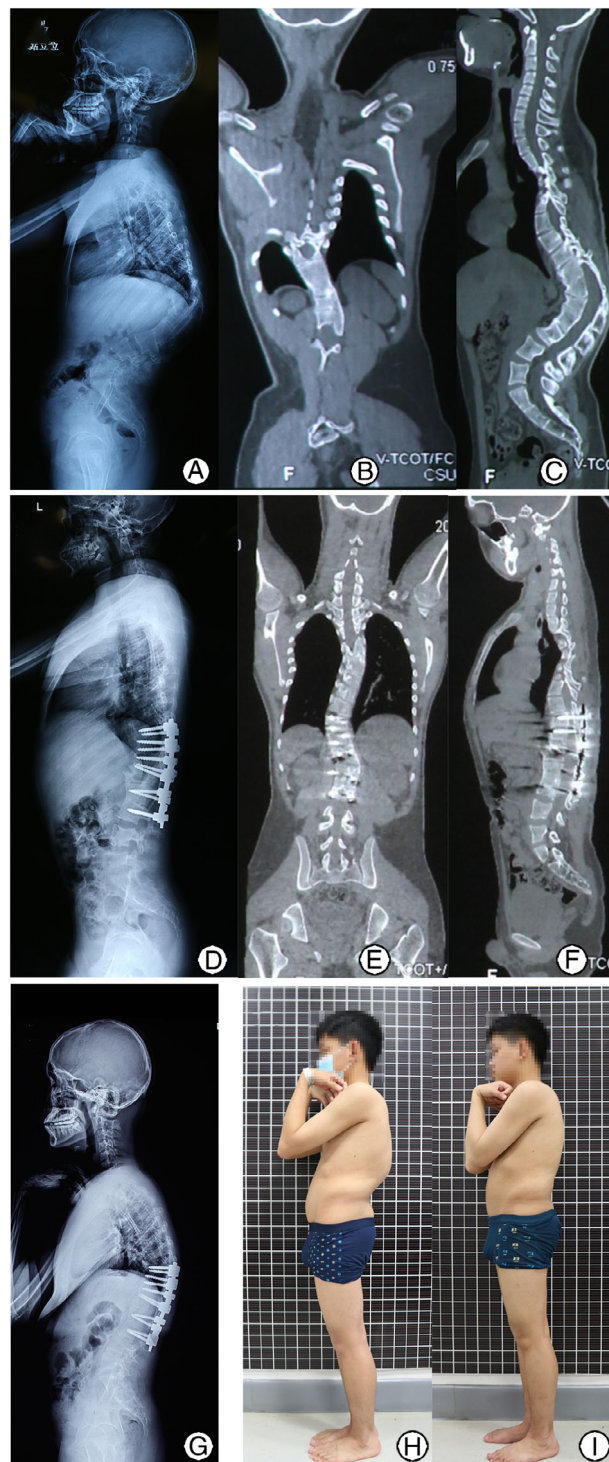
A 20–30-year-old case with T₁₀–T₁₂ congenital spinal angular kyphosis. (A–C) Preoperative lateral X-ray and 3D CT scan showed a T₁₀–L₂ congenital kyphosis, with a deformity angle of 88.3°. (D–F) Postoperative lateral X-ray and 3D CT scan showed DCVO at T₁₁–T₁₂ complex, with a deformity angle of 20.0°. (G) Latest follow-up X-ray showed a deformity angle of 29.9°. (H, I) Preoperative, postoperative, and last follow-up clinical photos.
